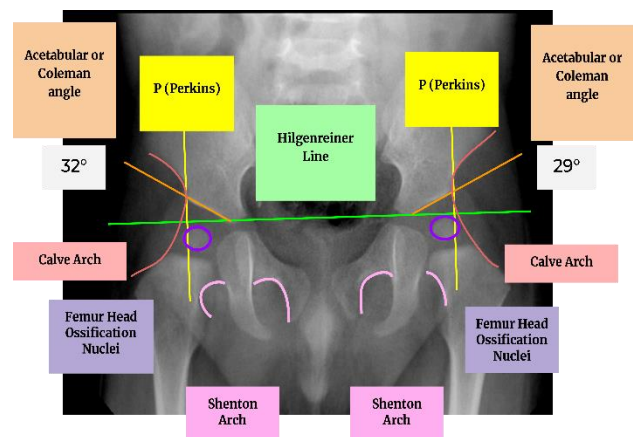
The accompanying X-ray corresponds to one of the study participants whose acetabular angles were measured using several standard techniques.
